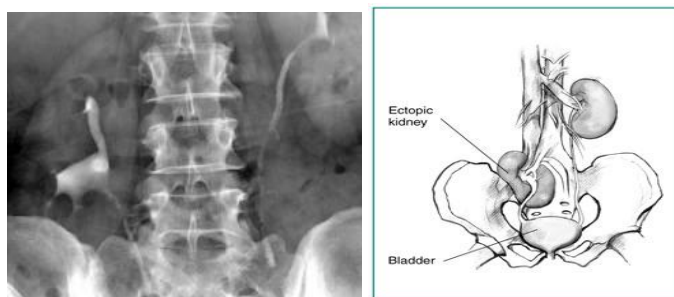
X-Ray KUB showing ectopic kidney.
